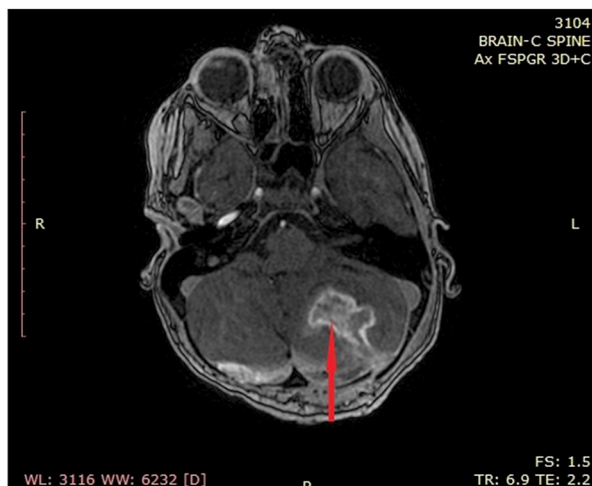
Post-operative magnetic resonance imaging (MRI), axial fast spoiled gradient echo-dual echo (FSPGR) 3D sequence after contrast administration, depicting the resection site of the tumor cavity without any residual remnants (red arrow).
